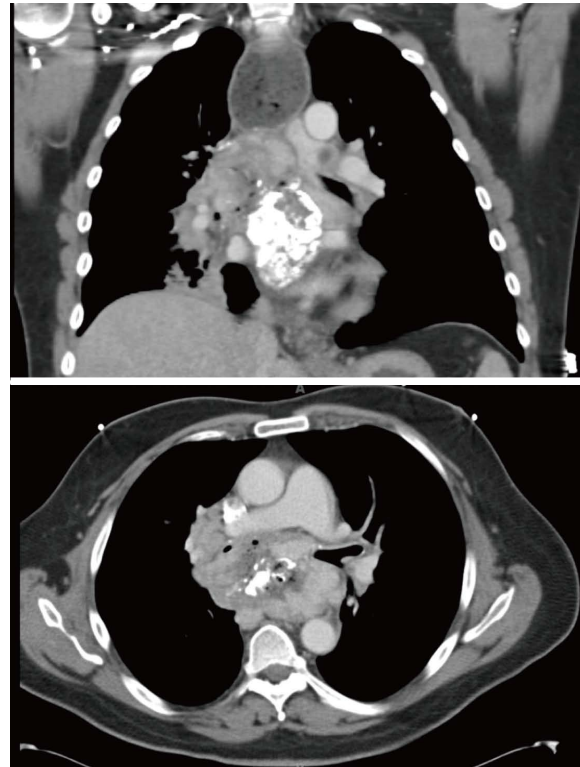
Coronal and axial computed tomography view of the partially calcified subcarinal mass surrounding the carina, the bronchi, and eroding into the esophagus (note the mediastinal air).
